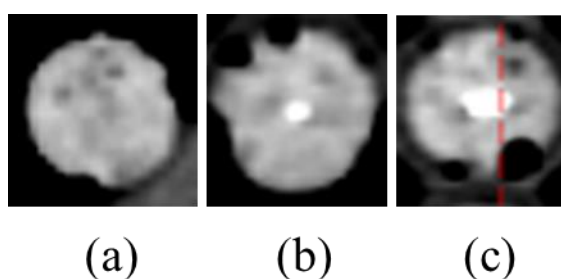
CT images of Iron NPs/PNIPAM system.
